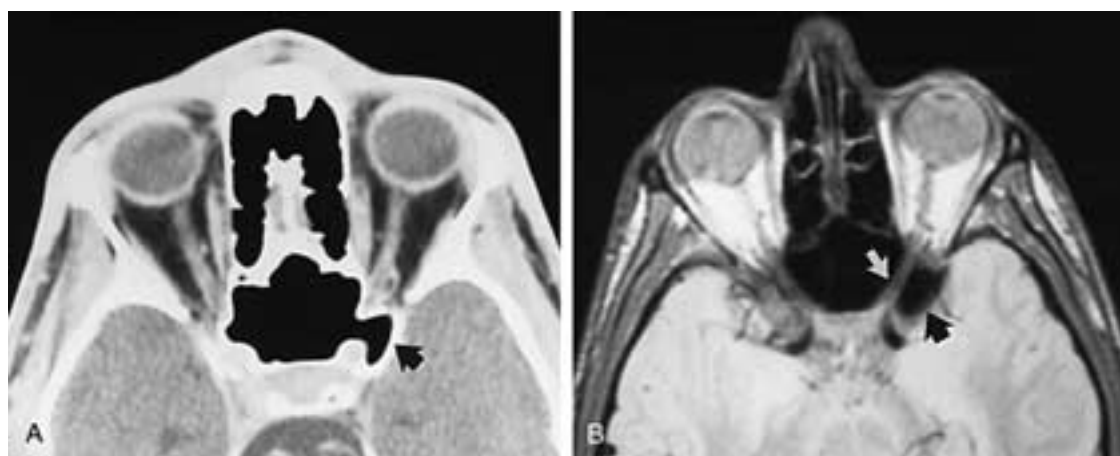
A, Sphenoid pneumosinus dilatans. Axial CT scan shows extension of sphenoid sinus pneumatization into the left lesser wing of sphenoid (*arrow*). B, Proton-weighted (2400/20, TR/TE) axial MR scan shows normal optic nerve (*white arrow*) and pneumatized lesser wing of sphenoid (*black arrow*). (From Mafee MF et al. Optic nerve sheath meningiomas: role of MR imaging. *Radiol Clin North Am* 1999;37:37–58.)
